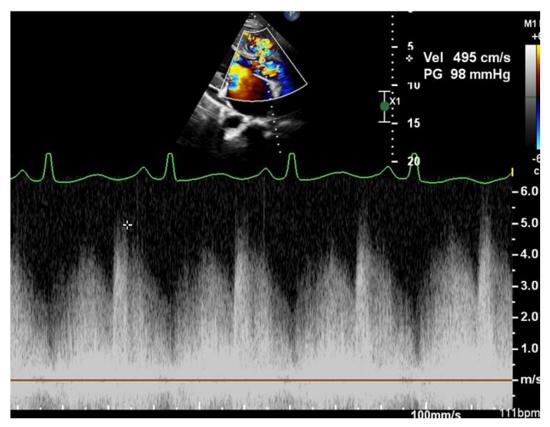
Two-dimensional TTE, parasternal long-axis view with color-flow Doppler-guided continuous-wave Doppler display, demonstrates the phasic flow across the VSD (higher velocity in systole) and the continuous flow from the ruptured SOVA (with the high diastolic flow velocity).
